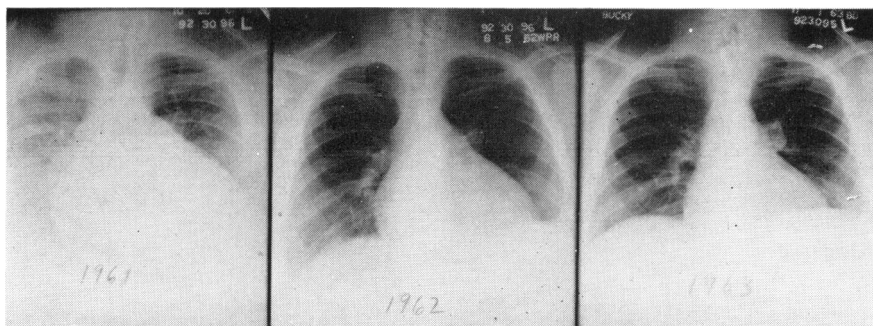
The chest roentgenograms in patient E.W. with obesity and alveolar hypoventilation. The film in 1961 was taken before weight loss during an episode of heart failure. The films in 1962 and 1963 were taken after weight loss; clinical evidence of heart failure was absent.
